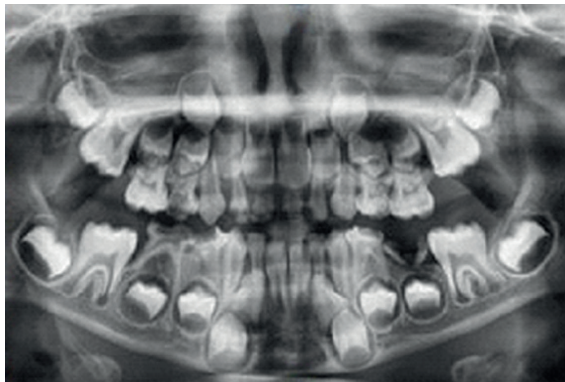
Preoperative dental panoramic radiograph
